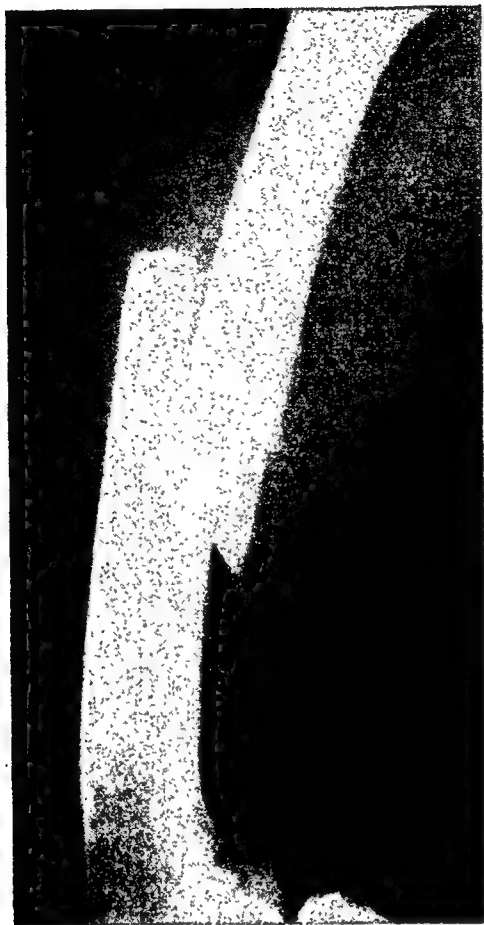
Intramedullary Nailing of Fracture of the Shaft of the Femur Complicated by an Undisplaced Fracture of the Neck of the Femur.* (A) Lateral view of comminuted fracture of the middle third of the shaft of the right femur. This was the only roentgenogram made on admission of the patient to the hospital. Note that the entire bone was not visualized.
